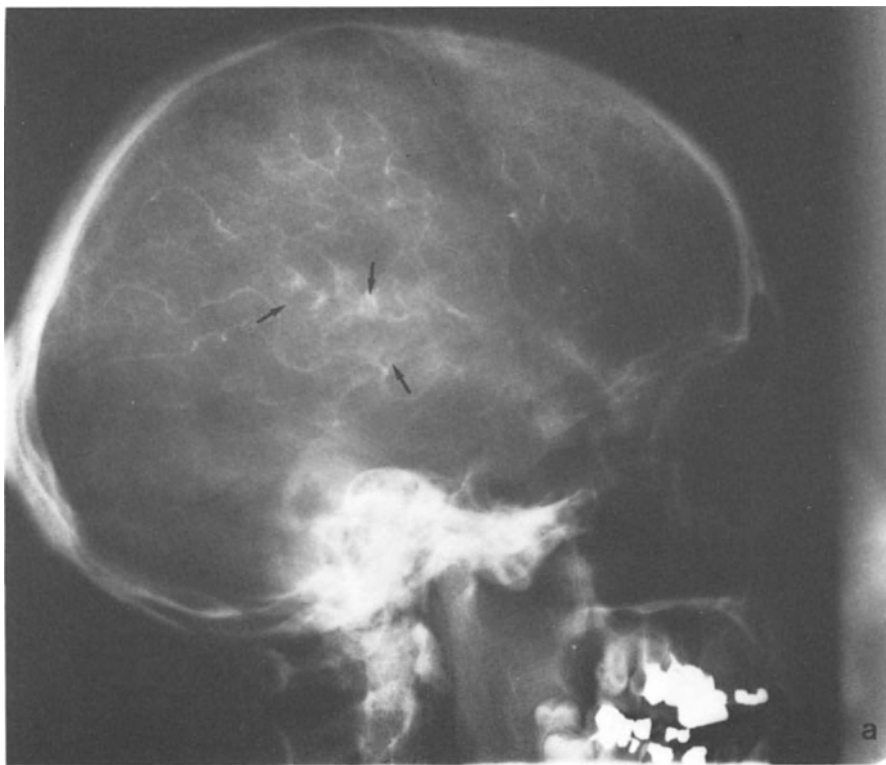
Intra-ventricular oligodendroglioma. a) Left carotid angiography (capillary phase): inhomogeneous vascularity (arrows). b) Left carotid angiography (venous phase): note the massive lowering of deep veins (arrows). c) Unenhanced CT in the same patient. d) Enhanced CT in the same patient
